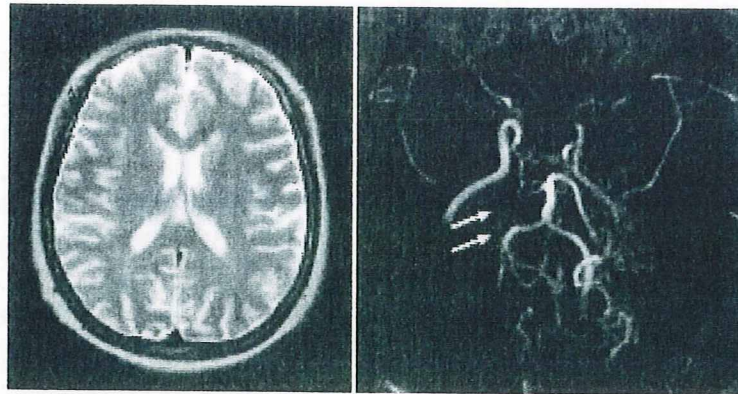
MRI (A) and MR angiography (B) of a 33-year-old female who developed transient left hemianopsia and numbness of the left extremities. Note severe stenosis of the right posterior cerebral artery (arrows).
